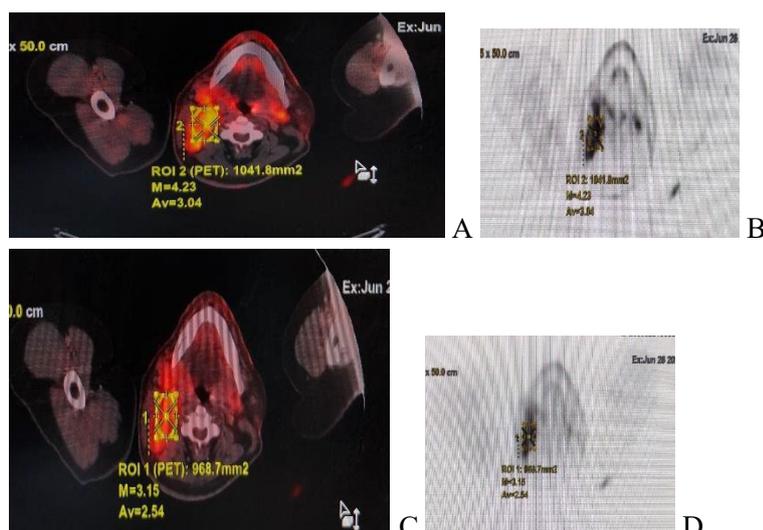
Measuring SUV_{max} at lymphoma lesion, (A&B). For Q.Clear measuring (C&D) for MAC-OSEM measuring.
